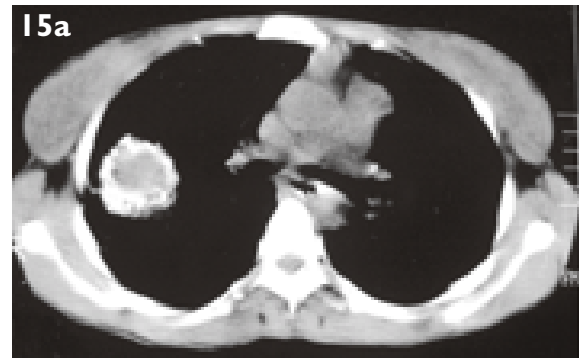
Disseminated hydatid disease. Enhanced axial CT images of the (a) thorax, (b,c) abdomen and (d) pelvis in a patient show involvement of liver, spleen, right kidney, pelvis, both ovaries and pouch of Douglas. Calcification is seen in some of the hepatic hydatid cysts, especially in the subdiaphragmatic location.
